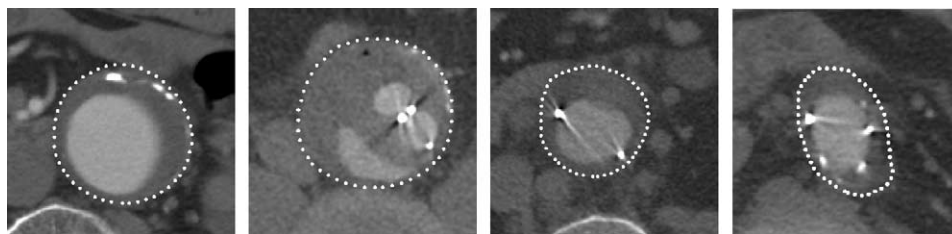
Four CTA slices of different patients, with manually delineated aneurysms. The left image is taken before surgery, the others are post-operative. The interior of the contour contains thrombus, contrast enhanced blood in the lumen and possibly in endoleaks, calcification, and – post-operatively – metal graft markers and attachment systems. Neighboring structures are the spinal column, blood vessels and intestines. All CTA images in this paper have been contrast stretched for better visibility of the thrombus.
